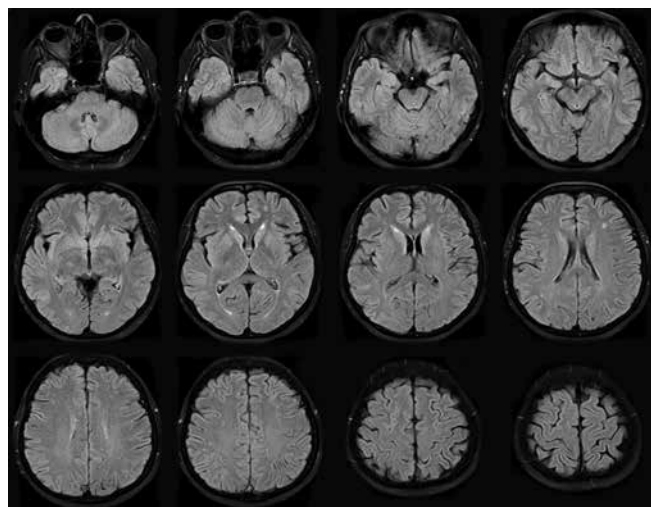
MRI images 3 weeks after developing PRES revealed significant improvement.
